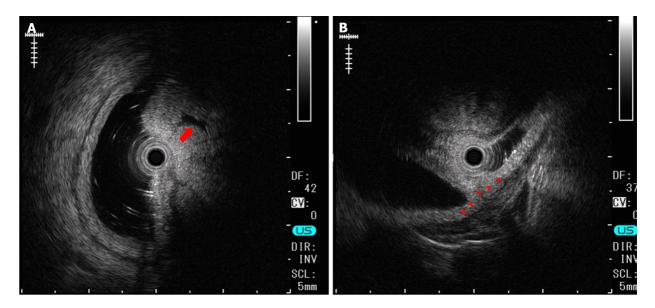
Endoscopic ultrasonography. A: Endoscopic ultrasonography revealed that the lesion had relatively high echogenicity with a cystic component (arrow) inside; B: At the base of the lesion, a slight elevation of a low echogenicity layer that was suggestive of the muscular layer was seen (arrowhead).
